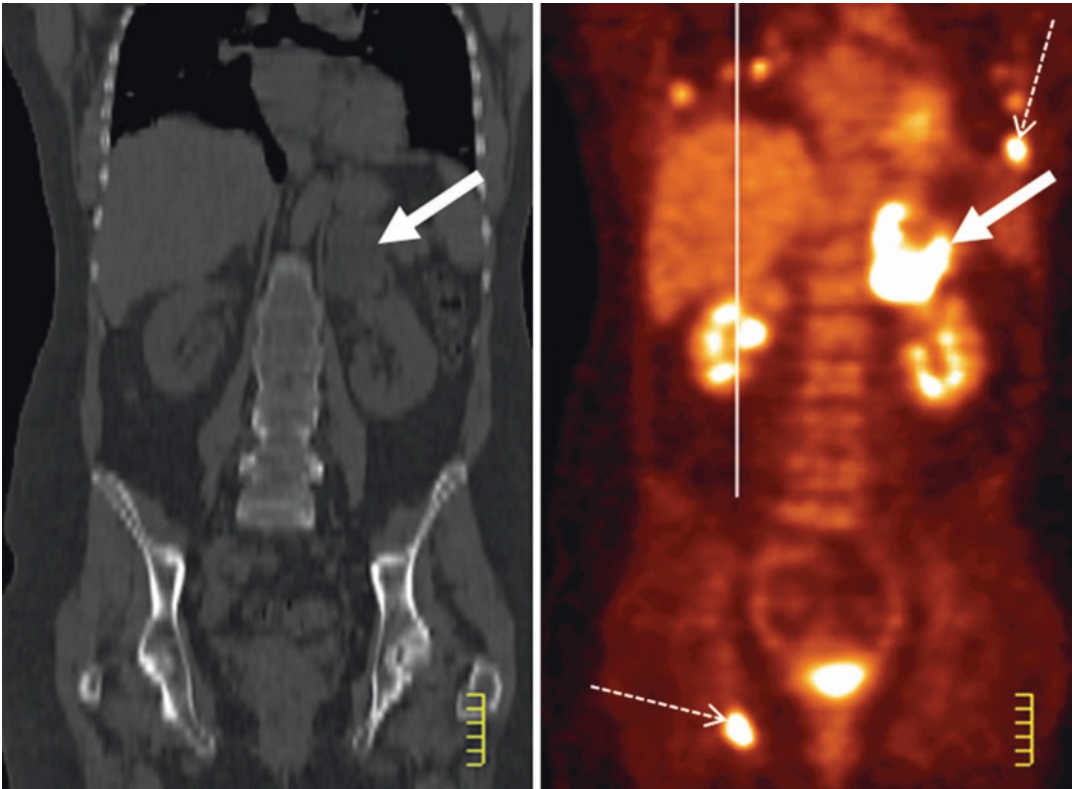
FDG-PET scan of a left stage 4 adrenocortical cancer (white arrow) with distant metastasis (dotted thin arrows) (right image: CT-scan; left: FDG-scintigraphy)
